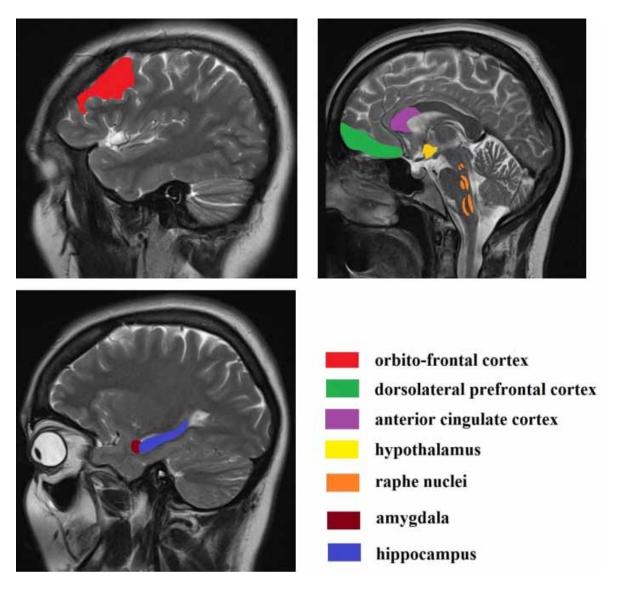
Brain MRI scans – sagittal views. Region highlighted represented approximate location of the important areas involved in MDD (personal collection)
